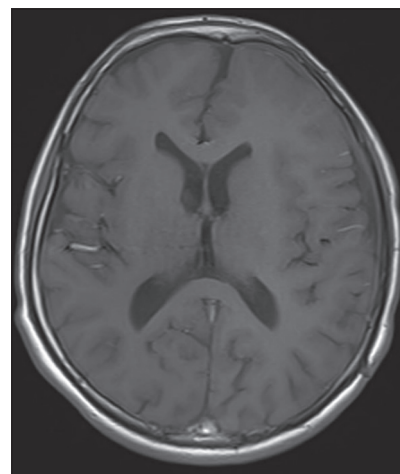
Three months later, control magnetic resonance imaging. After the surgical evacuation
